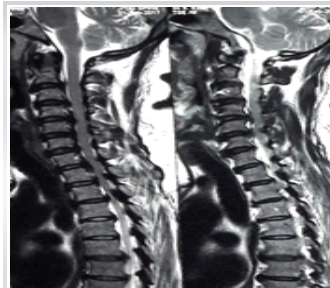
Pre op MRI showing Multilevel cervical OPLL with cord compression and signal change
